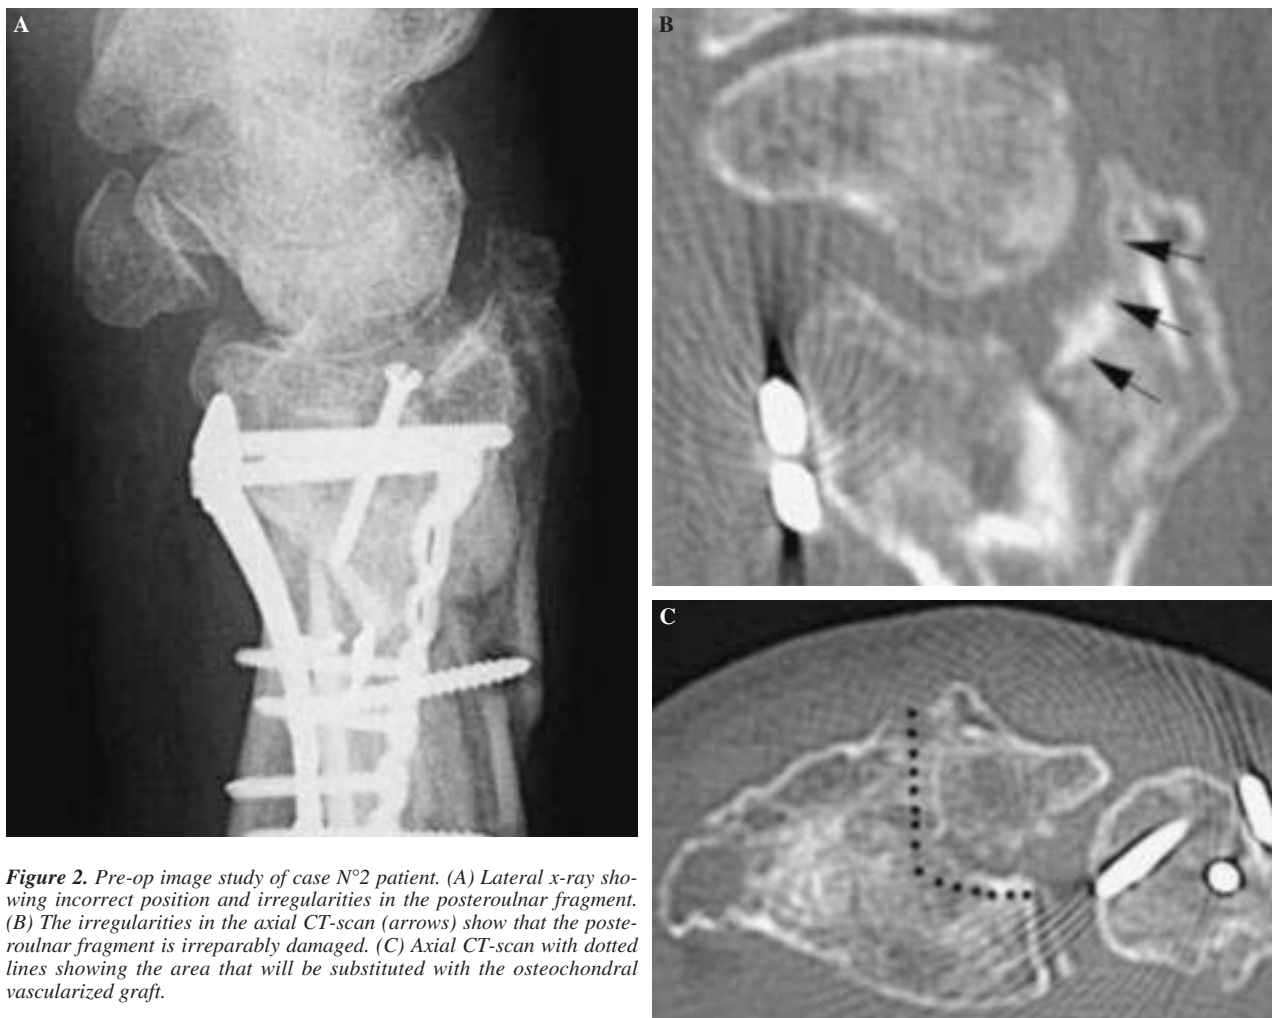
Pre-op image study of case N°2 patient. (A) Lateral x-ray showing incorrect position and irregularities in the posterolateral fragment. (B) The irregularities in the axial CT-scan (arrows) show that the posterolateral fragment is irreparably damaged. (C) Axial CT-scan with dotted lines showing the area that will be substituted with the osteochondral vascularized graft.
